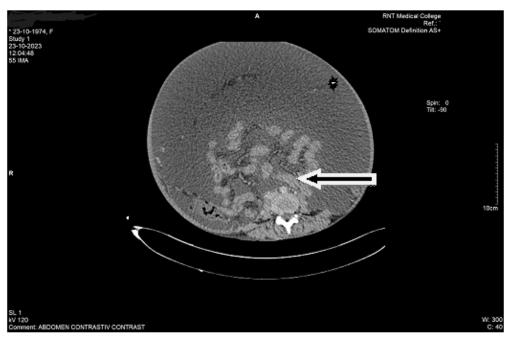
Shows axial contrast enhanced CT scan of the abdomen in which the asterix shows gross ascites and black arrow demarcates the clumped small bowel loops.
